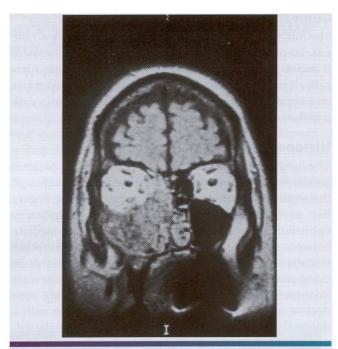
Inverted papilloma. T1-weighted coronal MRI showing a tumor of the right lateral nasal foss a. The tumor fills the right maxilla and ethmoid sinuses and involves the floor of the orbit. (Courtesy of Dr. Pamela Van Tassel.)
